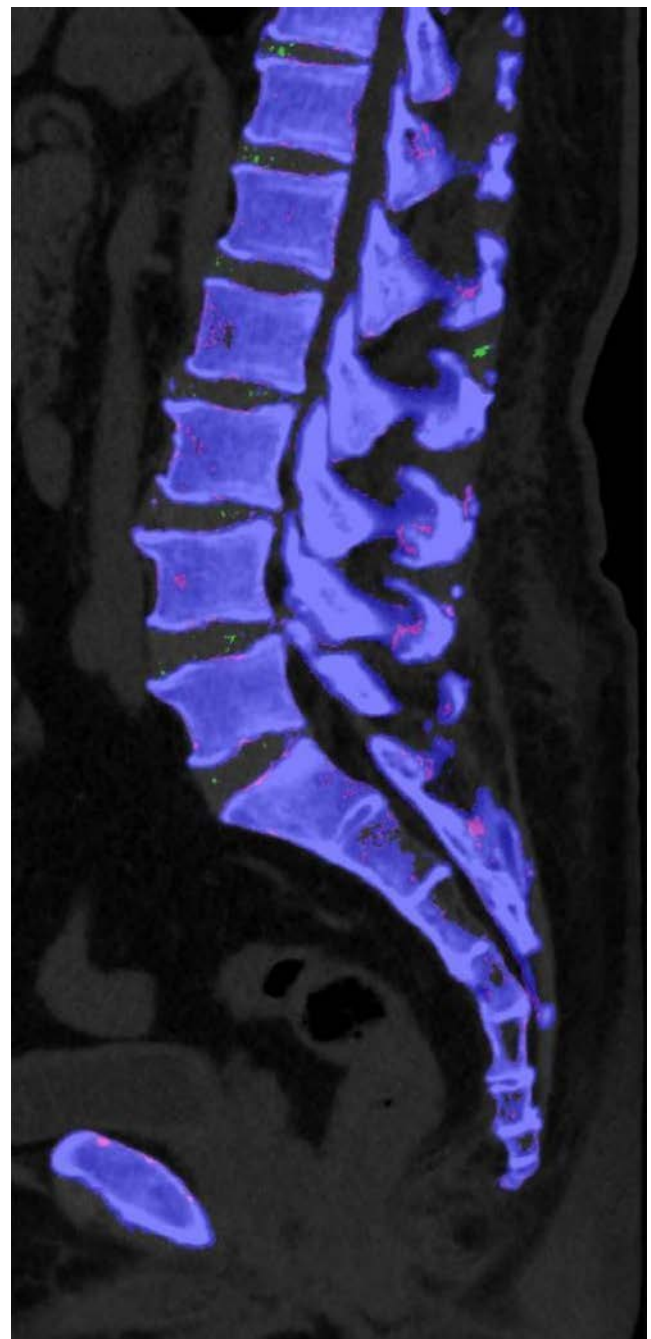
Dual-Energy Computed Tomography Scan of the Lumbar Spine showing Urate Deposits at the L1/2 Supraspinous Ligament and Lumbar Discs, on Background of Degenerative Disease.
